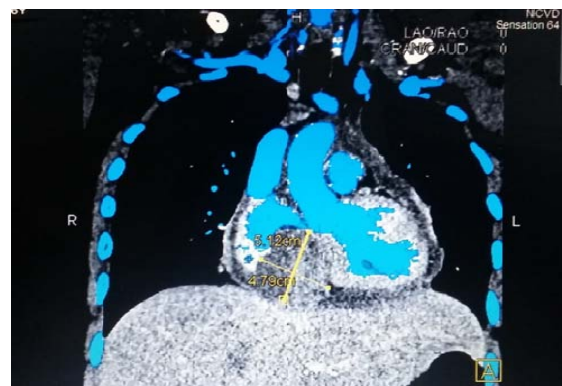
Computed tomography scan showing diffuse intra-cardiac mass involving the right atrium, inter-atrial septum, inter-ventricular septum, superior vena cava and left innominate vein and thrombus in the left sub-clavian vein, Bangladesh, 2020.
